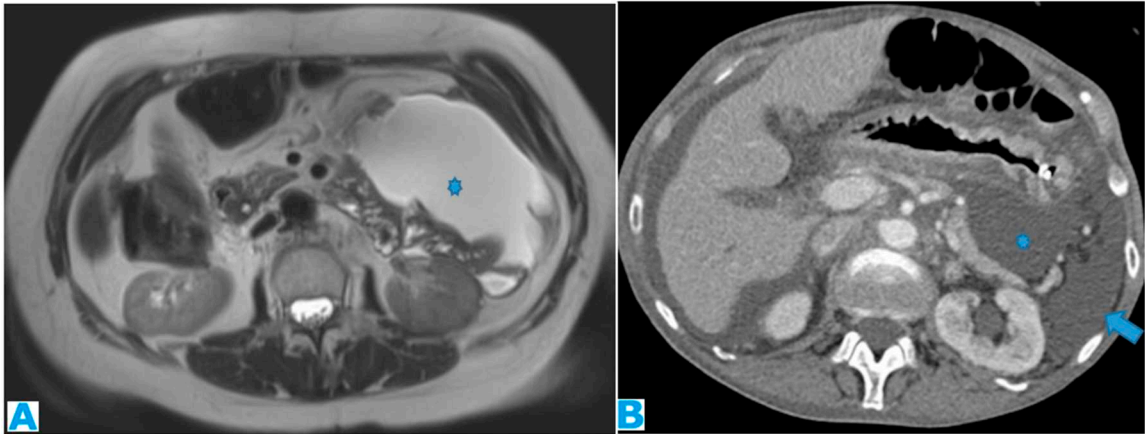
Axial T2WI (A). PC from ovarian adenocarcinoma : Loculated ascites within the mesentery (*). Axial CE-CT (B). PC from breast carcinoma: Concomitant ascites within greater (arrow) and lesser (*) sacs.
